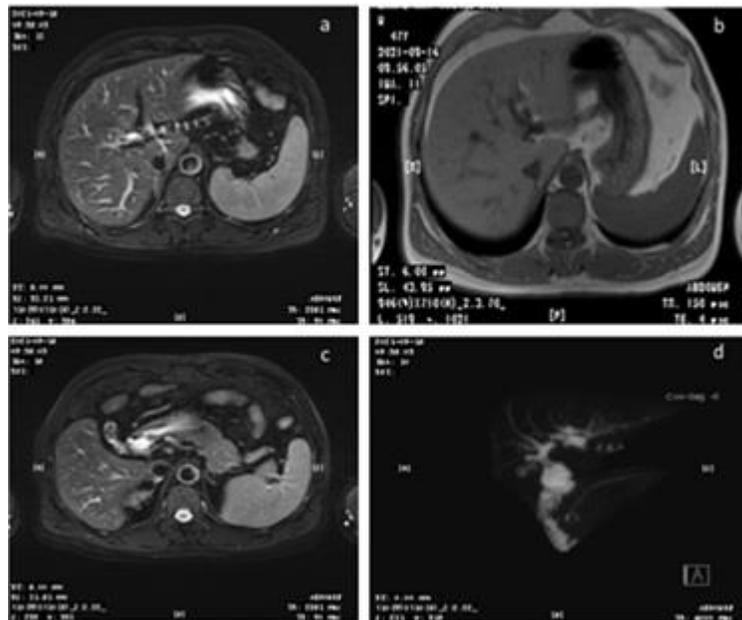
a~b: MRI showed a low-density continuous tubular structures extending from the left hepatic lobe to the stomach. c : The gallbladder is small in volume, and multiple low-signal shadows can be seen in the gallbladder cavity. d: MRCP showed the left hepatic duct was downward confluence with the lesser curvature of the stomach, the pancreatic segment, the posterior segment of duodenum, the pancreatic segment and the inner segment of duodenal wall of the common bile duct are not shown, and the main and auxiliary pancreatic ducts of the pancreas are unobstructed.
